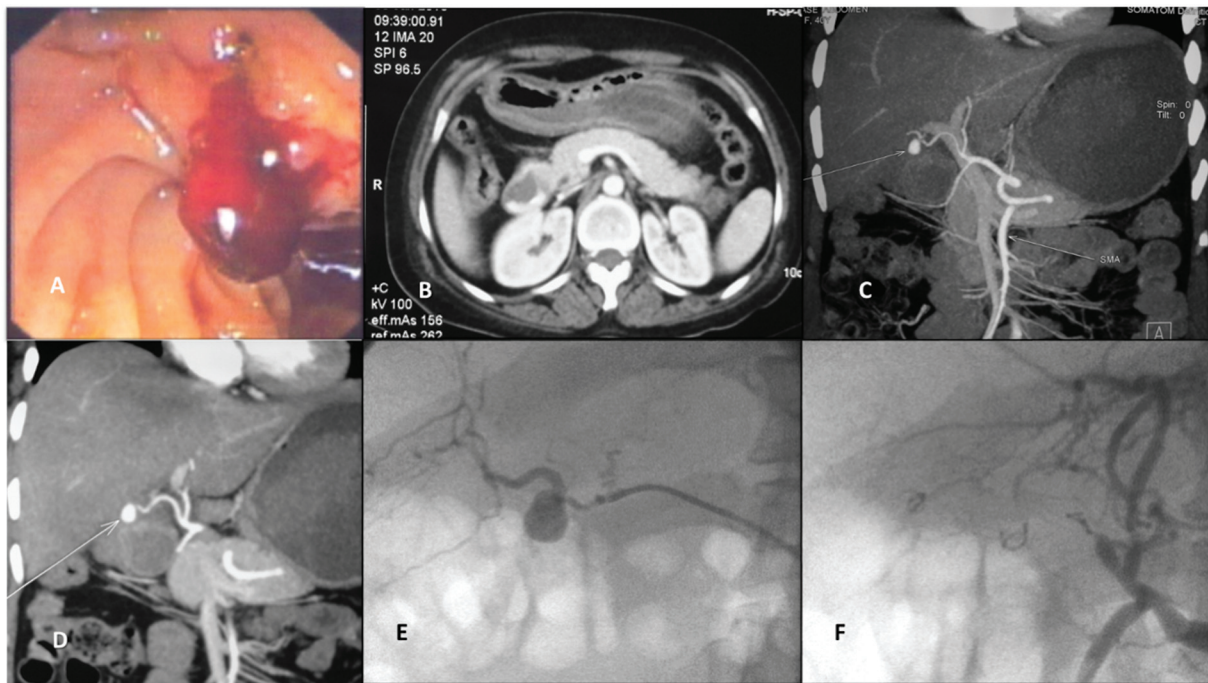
A 36-year-old man with vague upper abdominal pain and hematemesis, 2 weeks following laparoscopic cholecystectomy. (A) Upper gastrointestinal (UGI) endoscopy shows focal bulge with ulceration and oozing of blood from the duodenal wall. (B) Contrast-enhanced computed tomography (CECT) of the abdomen revealed a hyperdense collection in the duodenum in late arterial phase representing active bleed. No hyperdense collection is seen within the common bile duct, which rules out hemobilia. (C, D) Coronal reformatted image showing pseudoaneurysm (white arrow) arising from the right hepatic artery. This is closely abutting the duodenal wall. (E) Hepatic angiogram showing a pseudoaneurysm from the right hepatic artery and (F) postembolization of the same by the trap technique.
